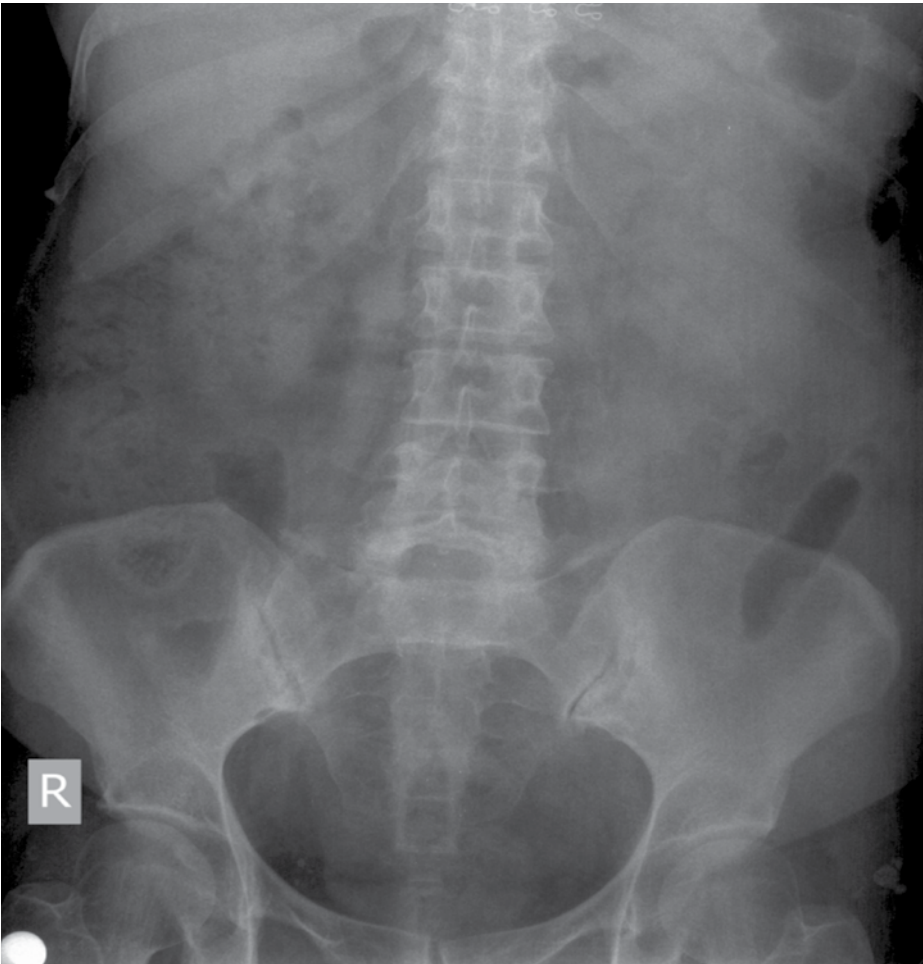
Bilateral grade 2 sacroiliitis with conventional x-ray
